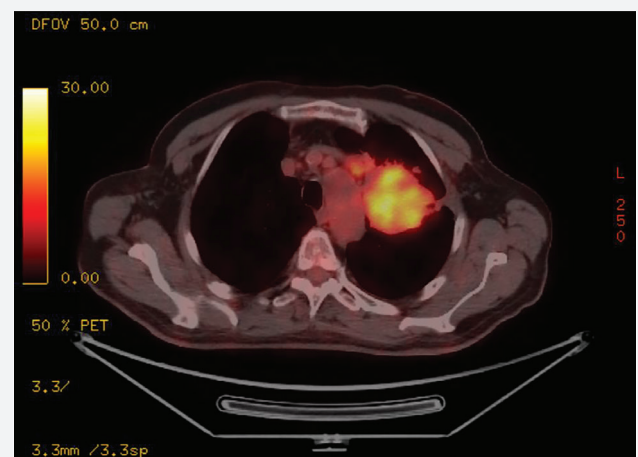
PET-CT image at diagnosis (04/04/2024) showing the primary lesion in the lung
